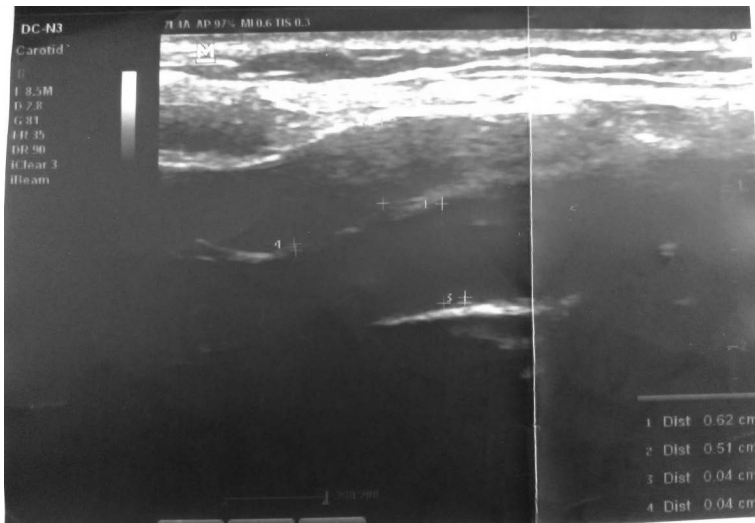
Doppler scan of carotid arteries with measurements.
